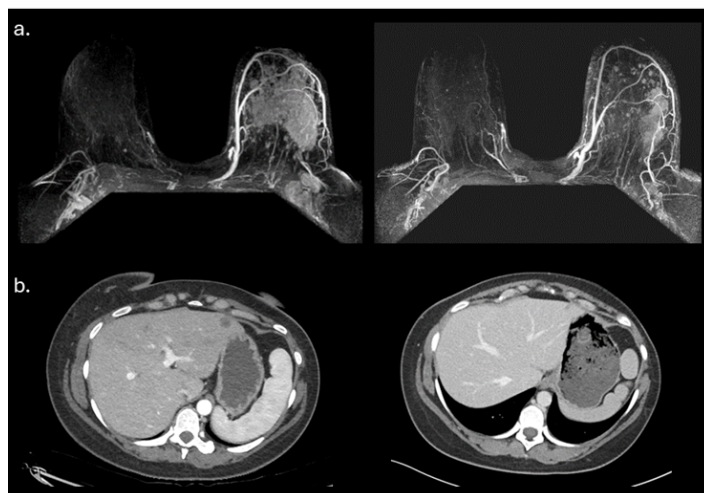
Patient 2: (a) Breast MRI pre-(left) and post-treatment (right) with cDC1 immunotherapy. Post-treatment MRI demonstrates decrease in size of the known malignant diffuse non-mass enhancement and axillary lymph node bulk. (b) CT Abdomen pre-(left) and post-treatment (right) with cDC1 immunotherapy. Post-cDC1 immunotherapy CT demonstrates a decrease in hepatic metastasis.
